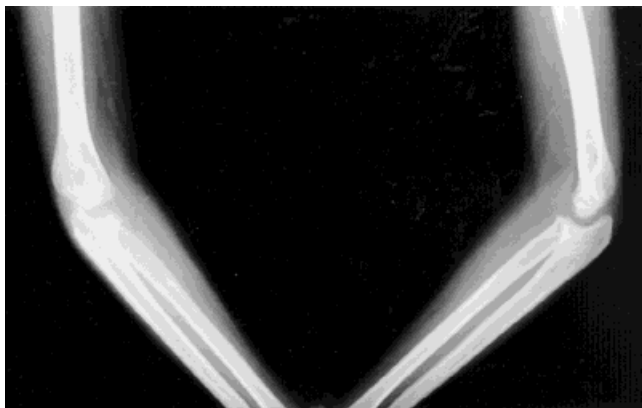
Patient III-3. Elbow roentgenographs showing radio-ulnar synostosis with proximal fusion.
